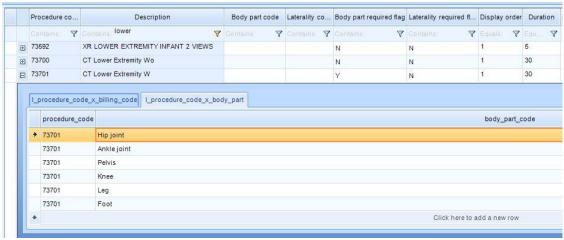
Available Body Parts for Procedure CT Lower Extremity W
